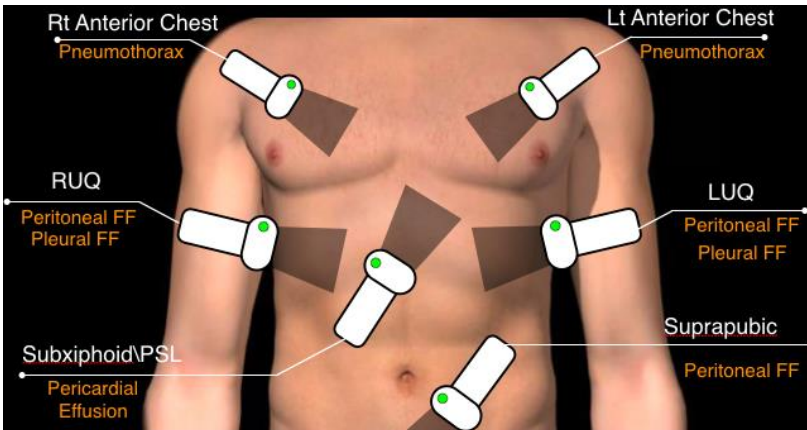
Five views of eFAST examination⁴: pericardial (subxiphoid/PSL), right flank (RUQ), left flank (LUQ), pelvic (suprapubic) and thoracic (right and left anterior chest) views. FF: Free fluid. PSL: Parasternal long
